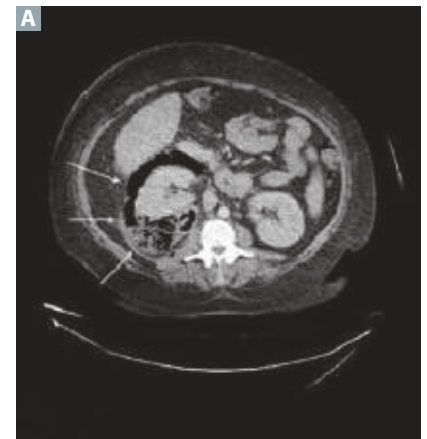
Pyelonephritis findings. (A) Emphysematous pyelonephritis. (arrows indicate air pockets from gas-producing bacteria) (B) Thyroidization of the kidney in chronic pyelonephritis. (C) Bear paw sign in xanthogranulomatous pyelonephritis. (Image A reproduced with permission from Ünliür EE, Karagöz A. Computed tomography in emphysematous pyelonephritis. *Pan Afr Med J.* 2015;22:186. Published 2015 Oct 23. doi:10.11604/pamj.2015.22.186.7902. Image B reproduced with permission from Bilgrami SM, Qureshi SA, Pervez S, Abbas F. Promoter hypermethylation of tumor suppressor genes correlates with tumor grade and invasiveness in patients with urothelial bladder cancer. *Springerplus.* 2014 Apr 5;3:178. doi: 10.1186/2193-1801-3-178. Image C adapted with permission from Ferreira L, Oliveira C, Cruz C, Pacheco A. Xanthogranulomatous pyelonephritis associated with hepatic dysfunction in pregnancy. *Case Rep Obstet Gynecol.* 2015;2015:936262. doi:10.1155/2015/936262.)
